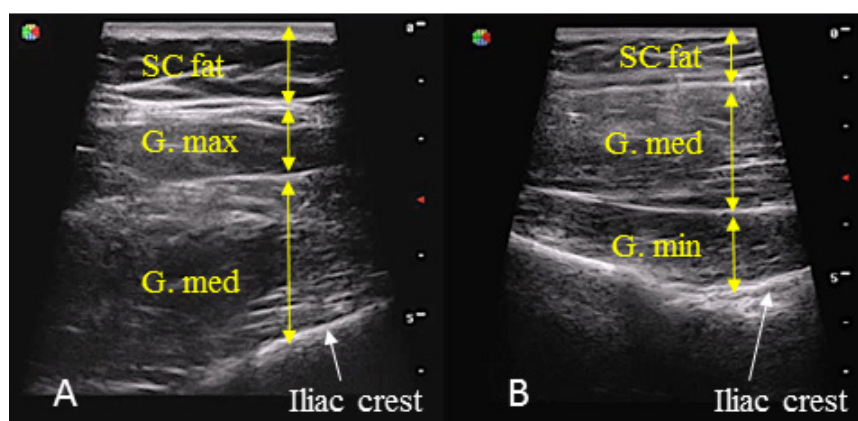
Ultrasound images for gluteal intramuscular injection sites using Sonoscape S6 Portable Digital Colour Doppler Ultrasound System, linear probe (L7-42), frequency 12.0–5.0 MHz. A: Dorsogluteal site; B: Ventrogluteal site, with subcutaneous fat (SC. fat), gluteus maximus (G. Max.), gluteus medius (G. Med.), gluteus minimus (G. Min.) and iliac crest labelled
